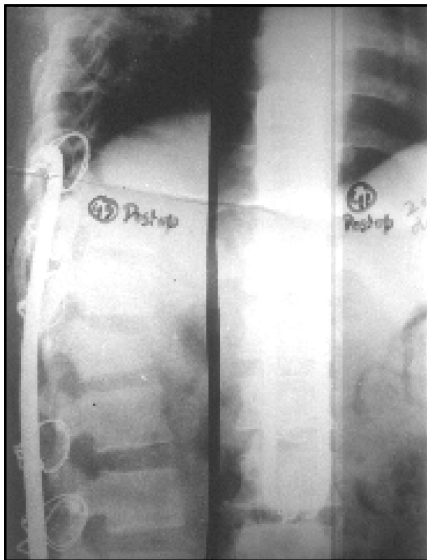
X-ray photograph of a patient managed with Hartshil's rectangle.
